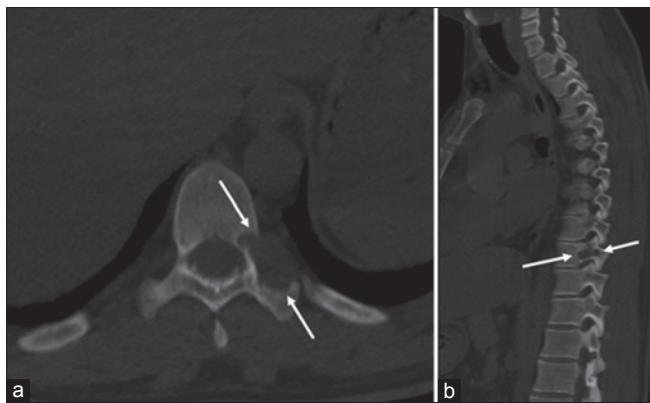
Computed tomography scan of dorsal spine, (a) axial and (b) sagittal views reveal an expansile lytic lesion showing thin sclerotic rim, involving the left posterior body, pedicle and transverse process of T12 vertebra with associated soft tissue lesion within (arrow). There was no evidence of any neural foraminal widening seen.
